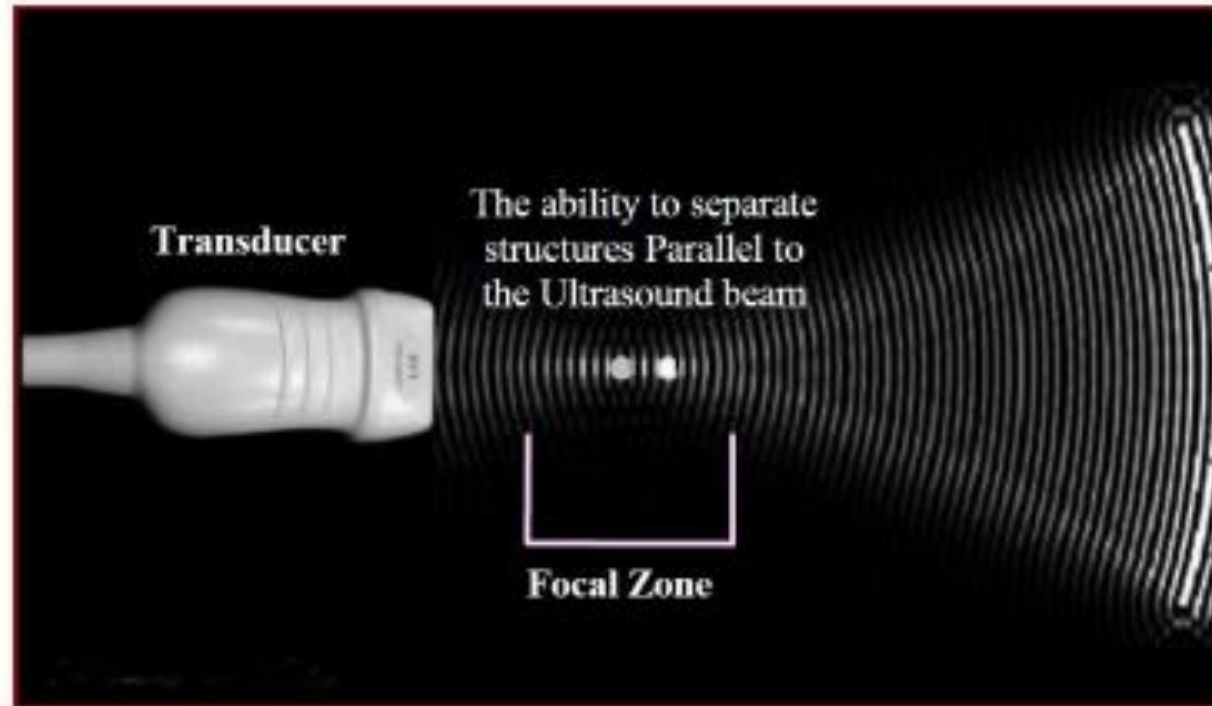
Axial resolution is the minimum separation between structures the ultrasound beam can distinguish parallel to the beam path.
